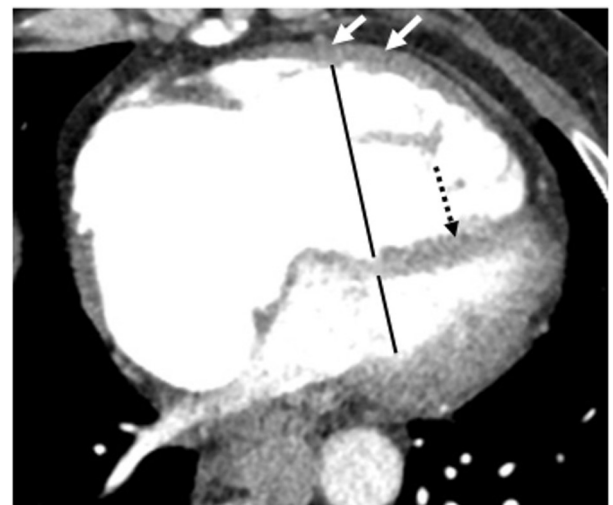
CT angiogram demonstrating increased right ventricle (RV) free wall thickness (white arrows), RV/left ventricle (LV) ratio >1 (black line), and bowing of the interventricular septum into the left ventricle (black dashed arrow) with an enlarged right atrium. RV and LV measurements are made perpendicular to the axis of the ventricular cavities from the endocardium to the interventricular septum. The widest diameter is used for each ventricle; of note, this may occur at different levels.
